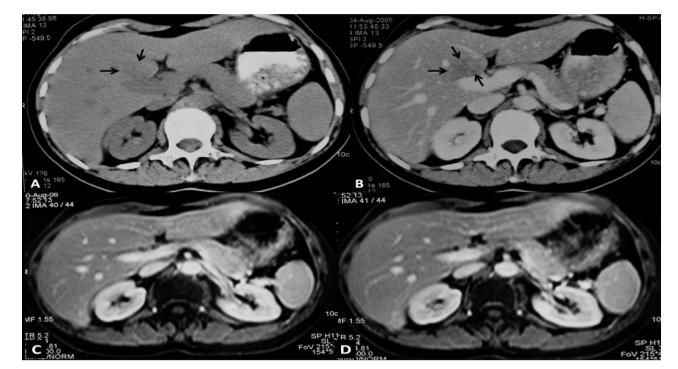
Breast cancer patient with liver metastasis. The pre-vaccination plain (A) and contrast-enhanced (B, portal phase of I.V. contrast administration) axial computed tomography images show the hypodense lesion anterior to the portal vein (arrows). The post-treatment (1 year later) contrast enhanced T1-w magnetic resonance consecutive images at the same anatomical levels (C, D) show normal appearing hepatic parenchyma.
